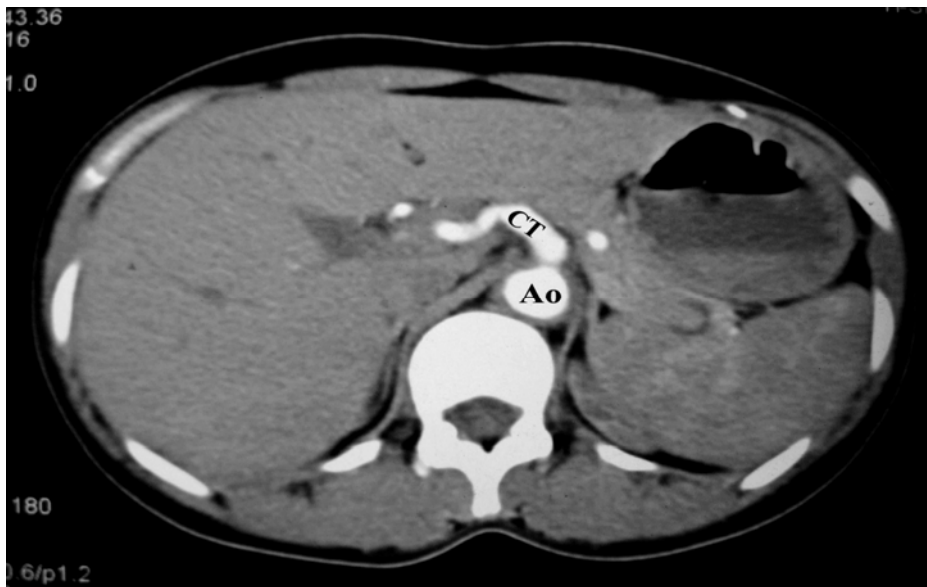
Axial section of CT angiogram showing origin of coeliac trunk from aorta.
